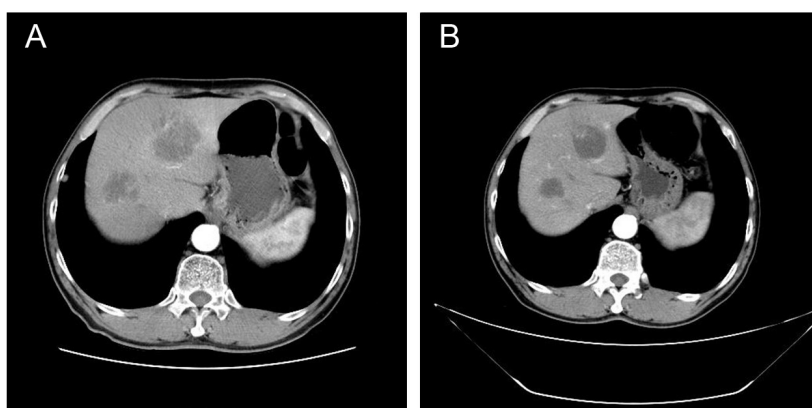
CT scan of a patient with liver metastasis achieved PR after 6 cycles of treatment. A) before treatment; B) after treatment.
